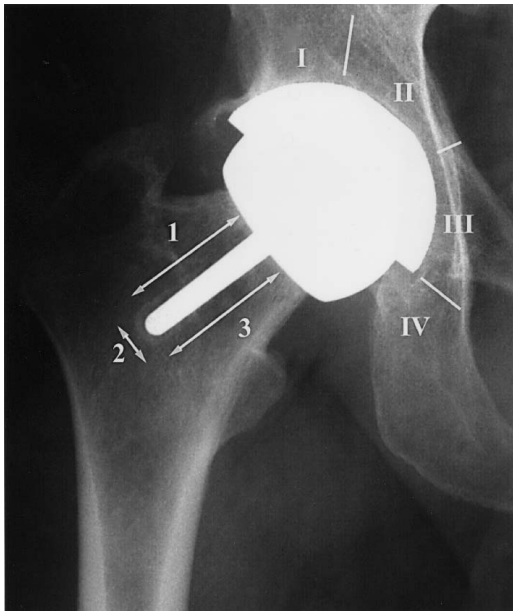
This radiograph shows the three femoral zones around the short stem. Radiolucencies can be seen in Zones 1 and 2. The four acetabular zones also are shown.
